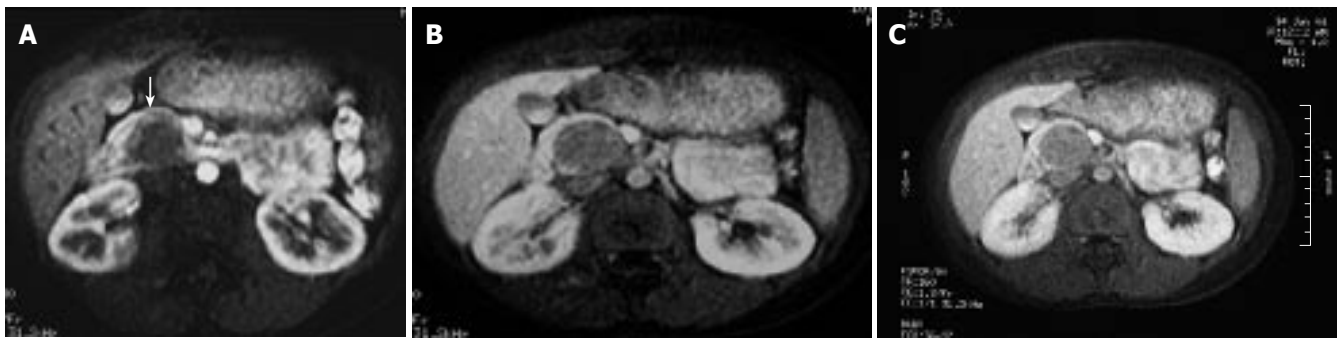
A: Arterial-phase contrast-enhanced T1-weighted image shows minimal peripheral thin contrast enhancement (arrow); B, C: Portal venous and equilibrium-phase contrast-enhanced T1-weighted images show that the mass enhances diffusely slightly.
